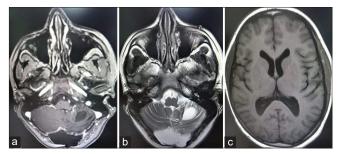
Postoperative magnetic resonance imaging (MRI) at 10 months follow-up. (a) T1-weighted contrast MRI showed postoperative changes with no enhancing nodule and no other hemangioblastoma. (b) T2 axial images showing postoperative changes and disappearance of edema. (c) T1 axial image showed resolution of hydrocephalus.
